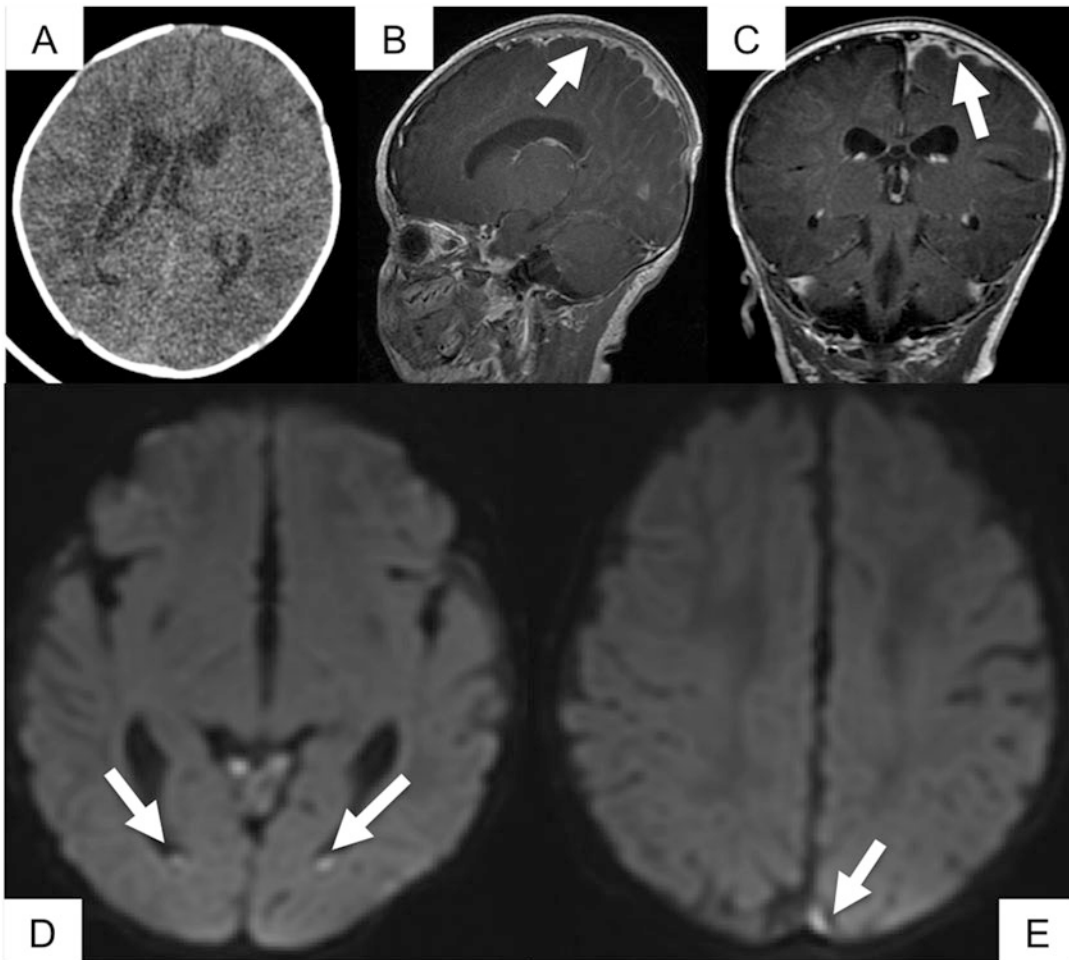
Bacterial meningitis. In this somnolent and febrile newborn, initial NCCT (a) only showed hydrocephalus. A contrast-enhanced MRI of the brain demonstrated abnormal leptomeningeal enhancement along the left frontoparietal convexity (*arrows*; b, c), consistent
